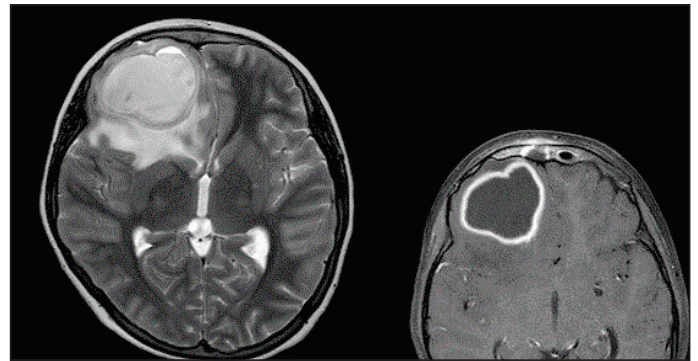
Contrast-enhanced brain MRI of a patient with *S. pyogenes* growth in brain abscess culture revealed right frontal abscess secondary to right frontal sinusitis and osteomyelitis in the anterior and posterior tabula of the right frontal sinus.
